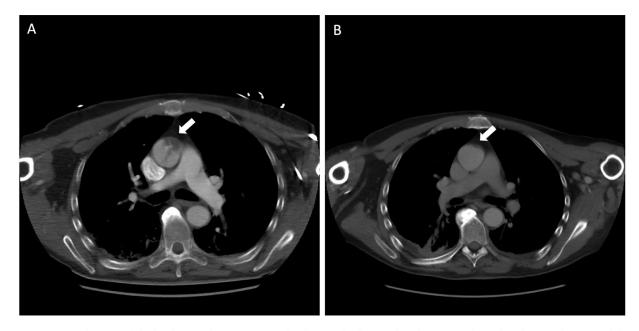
Case #2 (A) Axial section of the baseline CT thoracic angiography showing the floating thrombus (arrow) located in the ascending tract of the aorta (B) Follow-up CT scan obtained on day 11, showing disappearance (arrow) of the thrombus after anticoagulation treatment.
